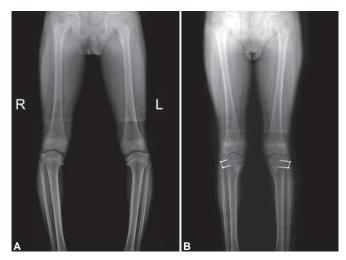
A, Preoperative X-ray of a 7-year-old boy with bilateral Blount's disease and B, 2 years follow-up X-ray after osteotomy showing normal alignment of the lower limbs
